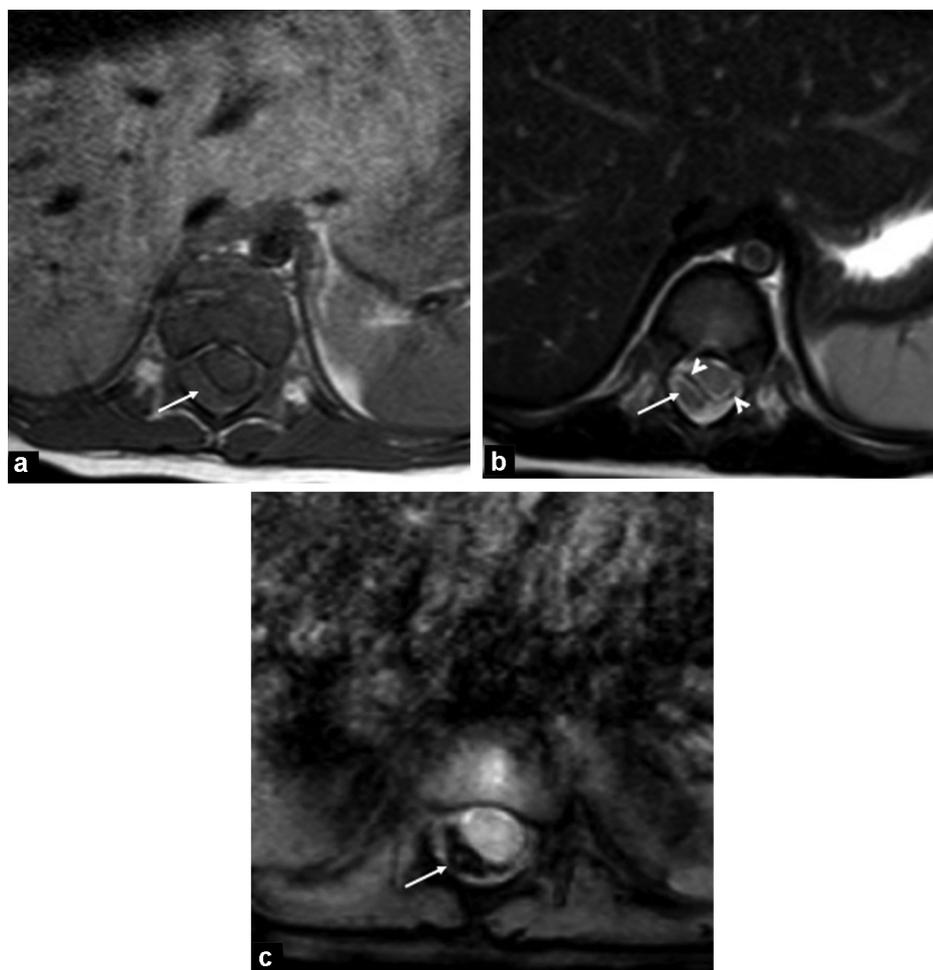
13-month-old boy with severe hemophilia A presenting with acute abdominal pain, refusal to stand up, and no history of trauma. T1-weighted (A), T2-weighted (B) and T2-weighted fat-suppressed spoiled gradient-echo (C) MR images in the transverse plane show spontaneous spinal epidural hematoma (arrows) in the posterior epidural space. The thin line corresponding to the dura mater (arrowheads on B) is displaced anteriorly.
